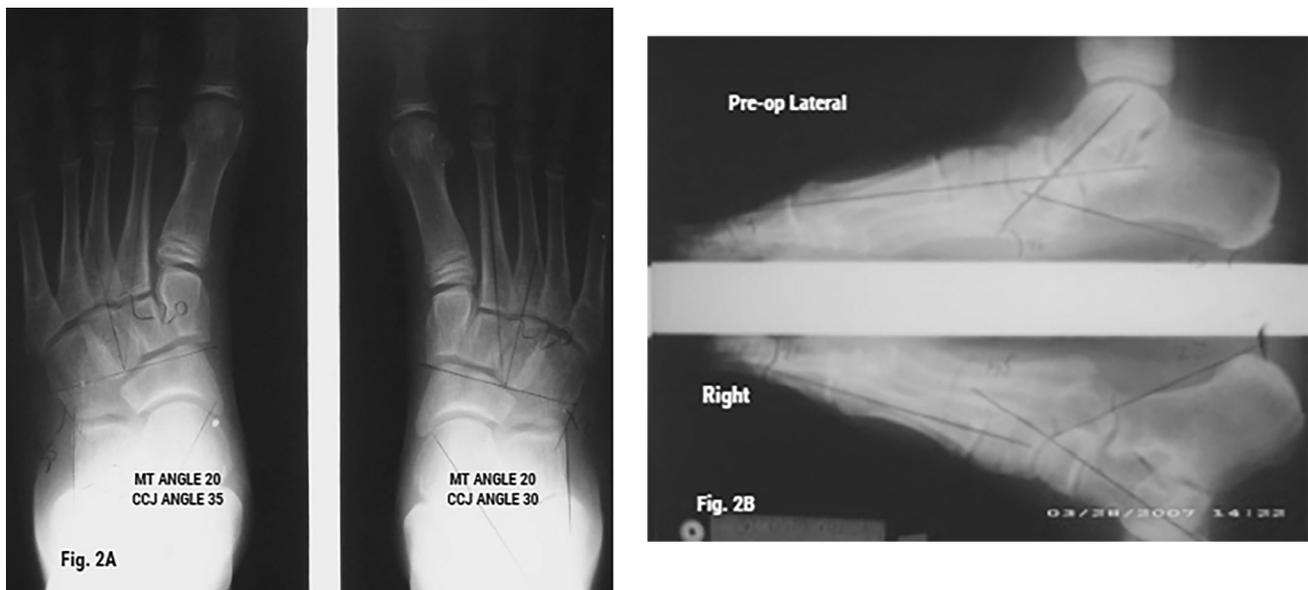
Radiographic imaging (A) confirmed the presence of a moderate bilateral skewfoot deformity. The dorsoplantar angular relationships were measured as follows: metatarsus adductus angles were 20° bilateral, and there was squaring off of all metatarsal bases 1 to 5. The first metatarsal proximal physal centers were open. The calcanealcuboid joint angles were right 30°, left 35°. The talonavicular joint was 45% subluxed, and the talo-first metatarsal angles were normal. Lateral radiograph (B) revealed both increased talar declination and decreased calcaneal inclination angles. There was superimposition of all metatarsal bases and an anterior break in the midtarsal joint.
